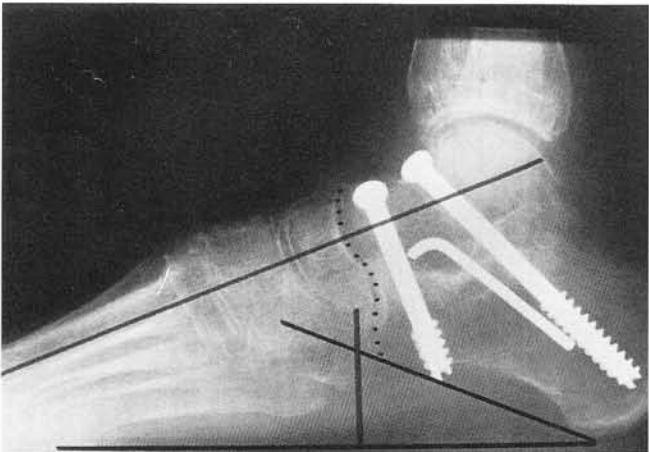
Lateral weight bearing radiograph taken several months postoperatively. Note the excellent correction of the deformity in contrast to figure 3B. The dorsal prominence at the Lisfranc articulation is clinically prominent and may require surgical resection in the future.
